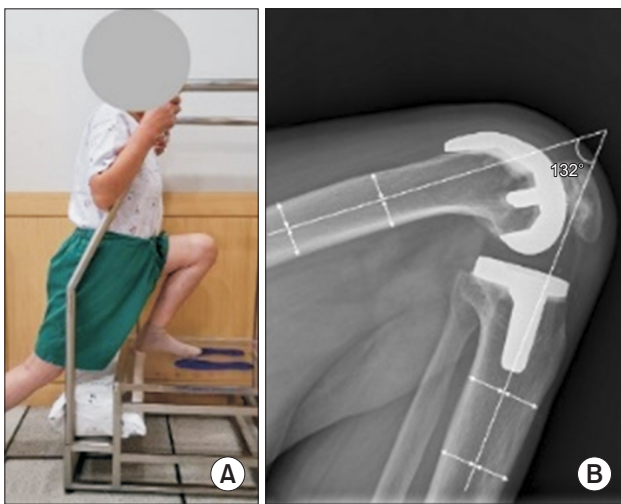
Scheme of the deep flexion angle. (A) Posture to take an active deep flexion weight-bearing lateral radiograph. (B) The angle formed by lines drawn along the mid-shafts of the tibia and femur on a lateral deep flexion radiograph.
